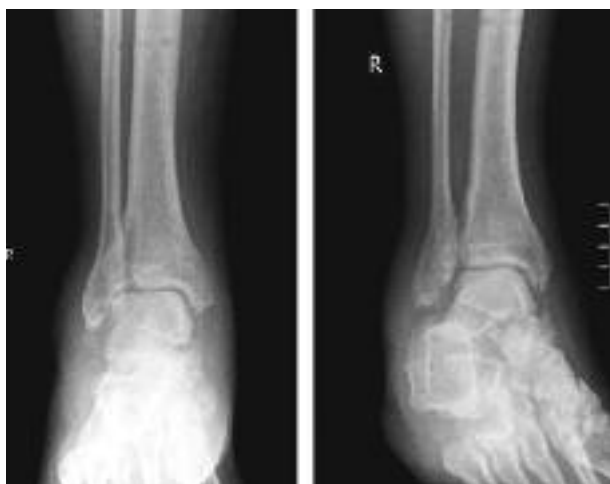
Case 2 : final radiographic appearance
